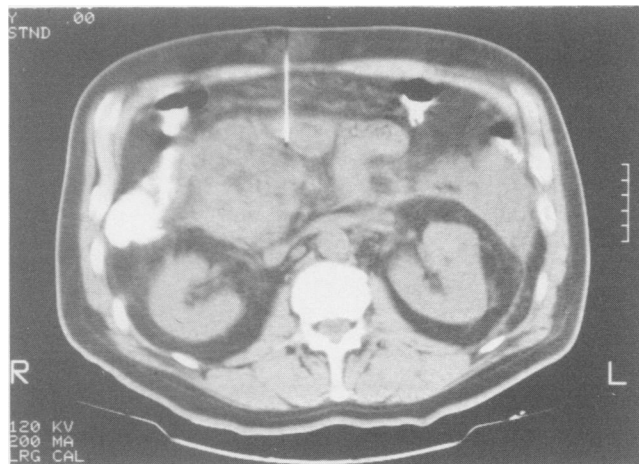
CT scan demonstrating infected necrosis in the head of the pancreas (marked by percutaneous needle). This patient developed fever and ileus 8 days after an uncomplicated CABG. He had no abdominal tenderness and did not complain of abdominal or back pain. He recovered slowly after surgical debridement.
